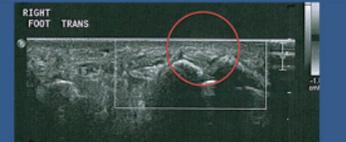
Ultrasound view of right 4th plantar plate tear 5 months after injection with mDHACM suspension (circled).
